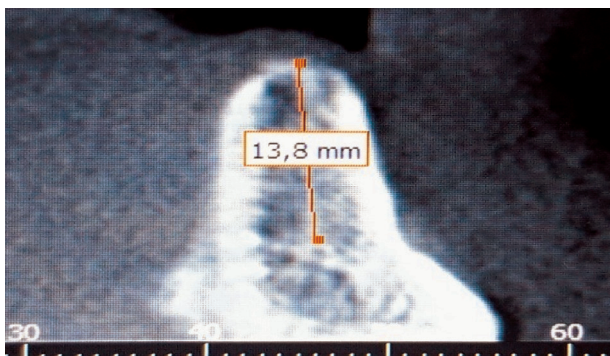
Vertical dimension of the alveolar ridge in the anterior mandible region. (CBCT image).
